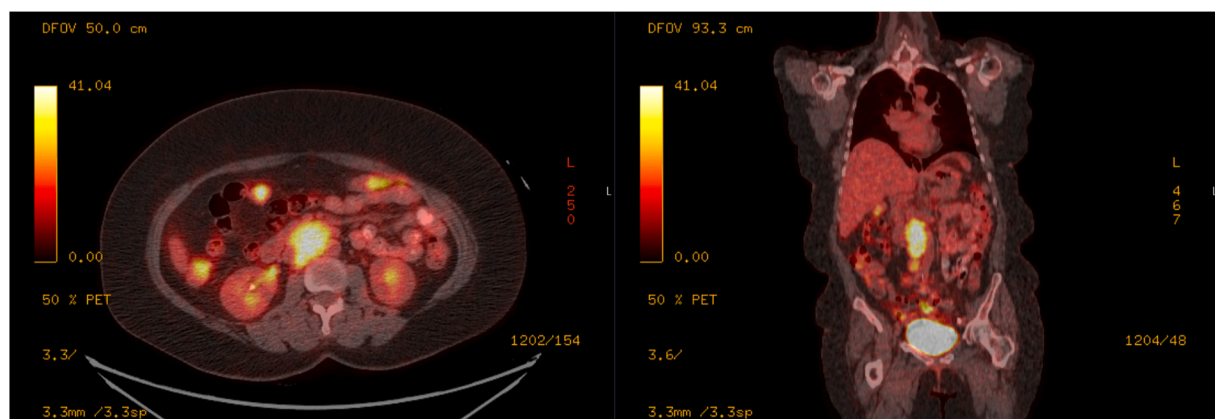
Initial PET/CT scan demonstrating retroperitoneal nodal paraganglioma conglomerate at the level of the renal arteries.
